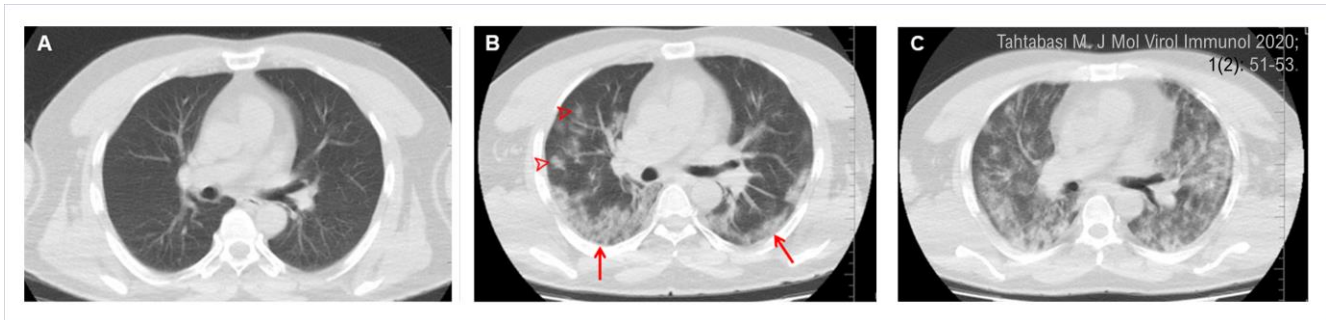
Initial and follow-up computed tomography (CT) images of a 48-year-old male patient with positive rRT-PCR. A) Initial CT (day one) shows that the lung is normal. B) CT on the fifth day showing patchy ground glass opacities (*arrowheads*) and Crazy paving pattern (*arrows*) posteriorly. C) CT on day 19 shows that the lesions have progressed, and acute respiratory distress syndrome has developed (at this stage, the patient is treated in the intensive care unit).
